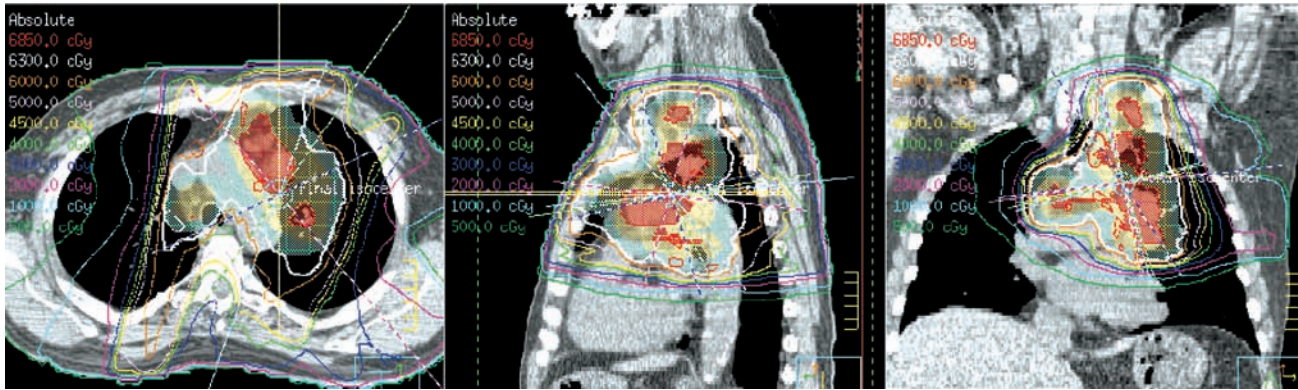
PET-CT guided target volume delineation. Please refer to full legend on page 23.
